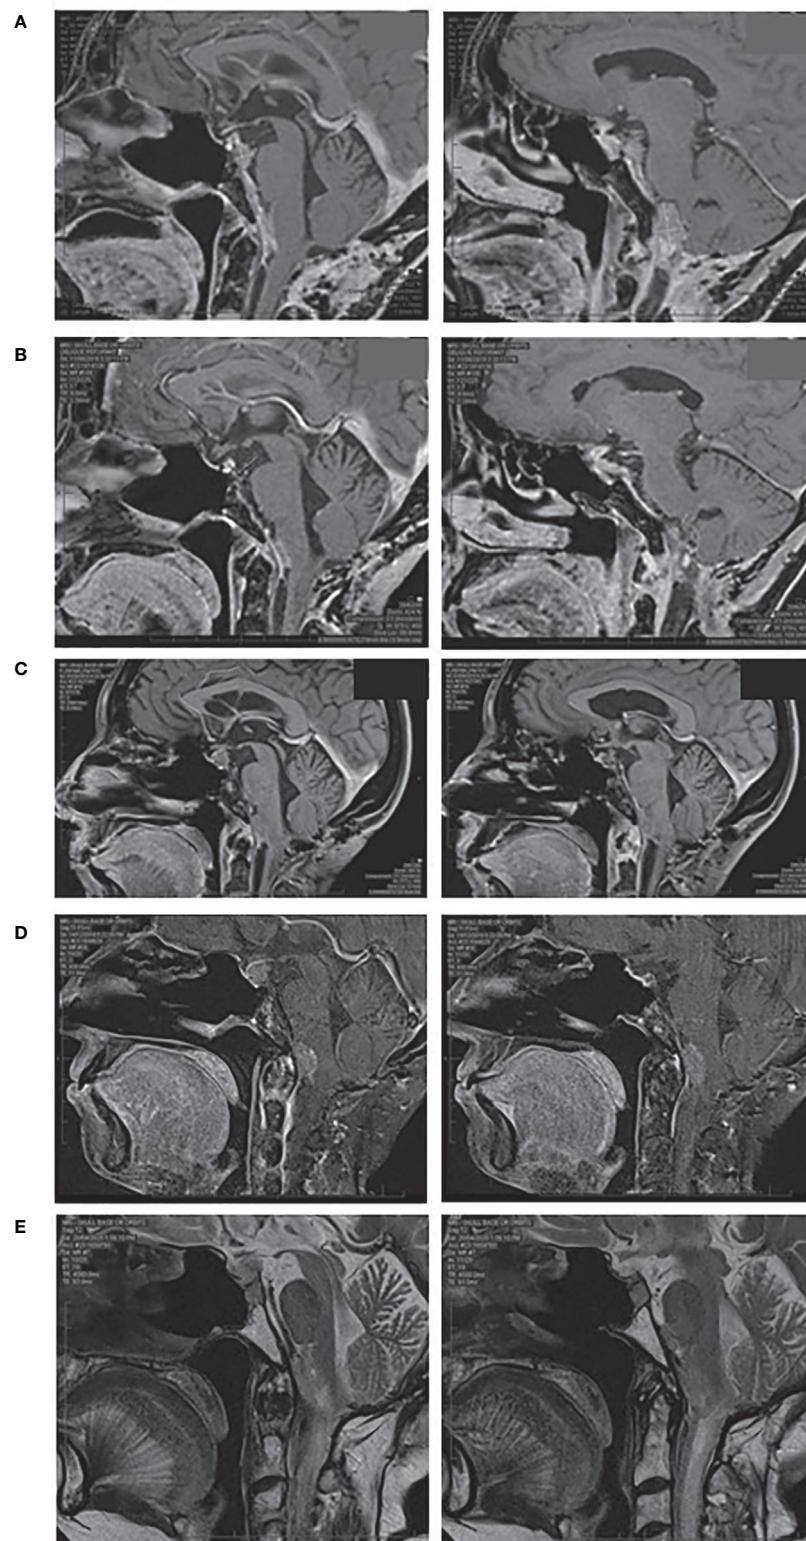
MRI pituitary, sagittal views. (A) October 2018 prior to dual ICI therapy, (B) June 2019 demonstrating response to dual ICI therapy, (C) September 2019 demonstrating progressive disease, (D) December 2019 demonstrating progressive disease following repeat dual ICI therapy, (E) April 2020 demonstrating stable disease following bevacizumab. (A–D) T1 weighted images post gadolinium, (E) T2 weighted images without gadolinium due to renal impairment.
